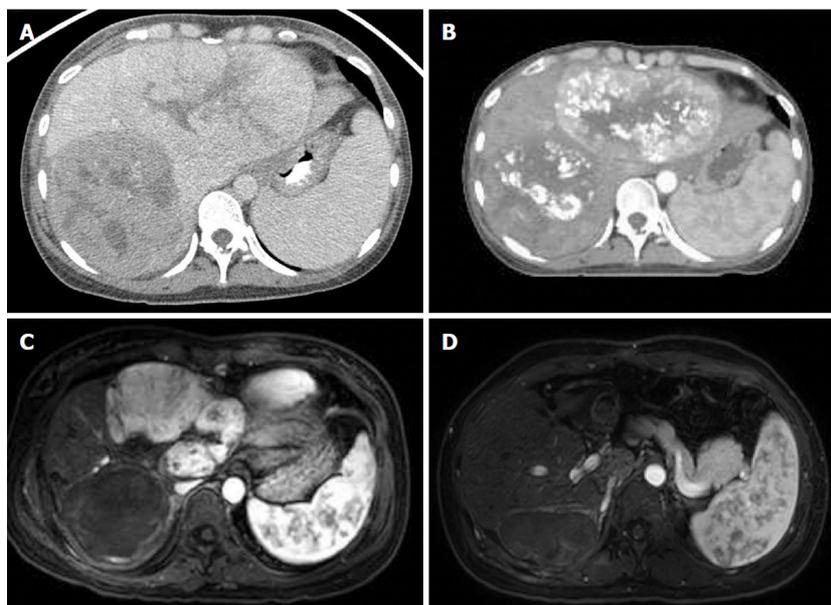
Initial portal venous phase contrast-enhanced computerized tomography showing bilobar lesions consistent with hepatocellular carcinoma. A: Arterial phase contrast-enhanced low-dose radiation therapy planning computerized tomography showing post-transarterial chemoembolization treatment changes to bilateral lobes 3 mo after diagnosis; B: Arterial phase T1-weighted fat-saturated post-contrast magnetic resonance imaging showing complete right lobar mass response following proton radiation therapy 6 mo after diagnosis; C: Axial arterial phase T1-weighted fat-saturated post-contrast magnetic resonance imaging showing no evidence of disease following left hepatectomy; D: Axial arterial phase T1-weighted fat-saturated post-contrast magnetic resonance imaging showing no evidence of disease 14 mo after diagnosis.
